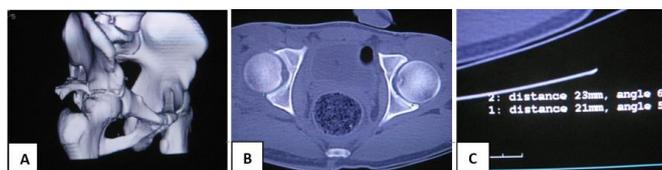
A, B: CT scan shows fracture of posterior wall of acetabulum. C: CT scan shows the distance measured from acetabular notch to the posterior border of the acetabulum. Distance is reduced on the fractured side.
